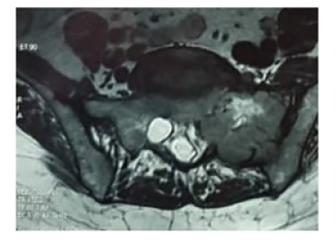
Axial lumbar MRI showing an osteolytic mass invading the left sacral regions S2 and S3 vertebrae.
